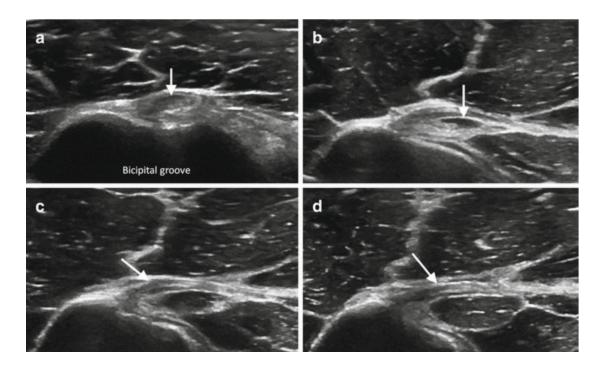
Normal transverse ultrasound appearance of the pectoralis tendon insertion. The bicipital groove is used as an anatomical landmark (\mathbf{a}, \mathbf{b}) . As we move the transducer inferiorly the pectoralis tendon (arrow) will cross the tendon biceps tendon (arrow) and insert in the lateral edge of the groove (\mathbf{c}, \mathbf{d})
